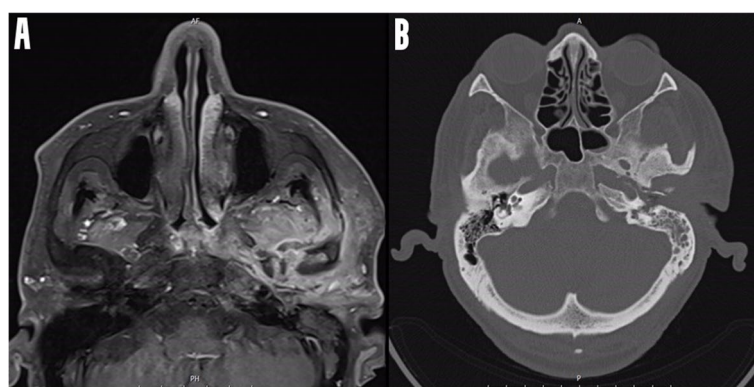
A Diffuse edema and post-gadolinium enhancement of the left skull base and soft tissue in T1 sequences. B The destructive changes in skull base and petrosal bone, and mastoiditis in computed tomography imaging
